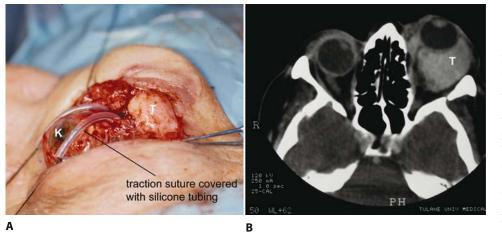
(A) Intraoperative and (B) CT appearance of a giant cell fibroblastoma. Note the well-delineated but not encapsulated fibrous tumor (T), which offers a very homogeneous appearance on CT because of its hypercellularity. The traction suture through the lateral rectus muscle was pulled medially for easy dissection of the lateral orbital mass; the silk suture was covered with silicone tubing to protect the cornea (K) during traction.
